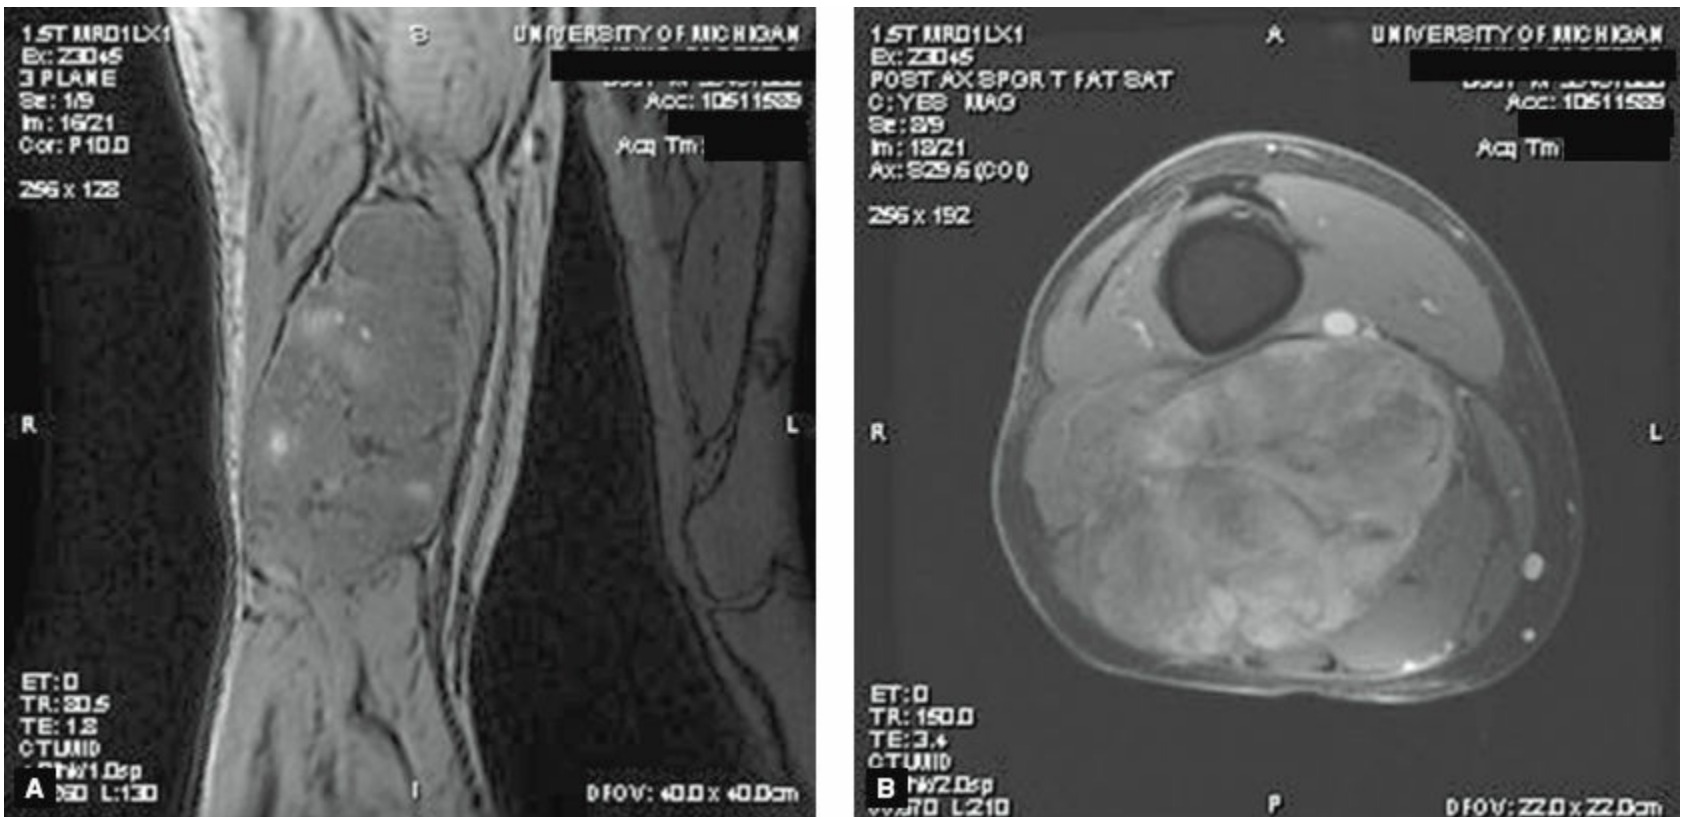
Extremity sarcoma. MRI demonstrates a 20-cm low-grade myxoid liposarcoma. A: Coronal reconstruction demonstrates location in the distal right thigh. B: Axial images show displacement of the popliteal vessels and vastus medialis anteriorly; the common tibioperoneal nerve and biceps femoris laterally; and, the semimembranosus and semitendinosus muscles medially.
